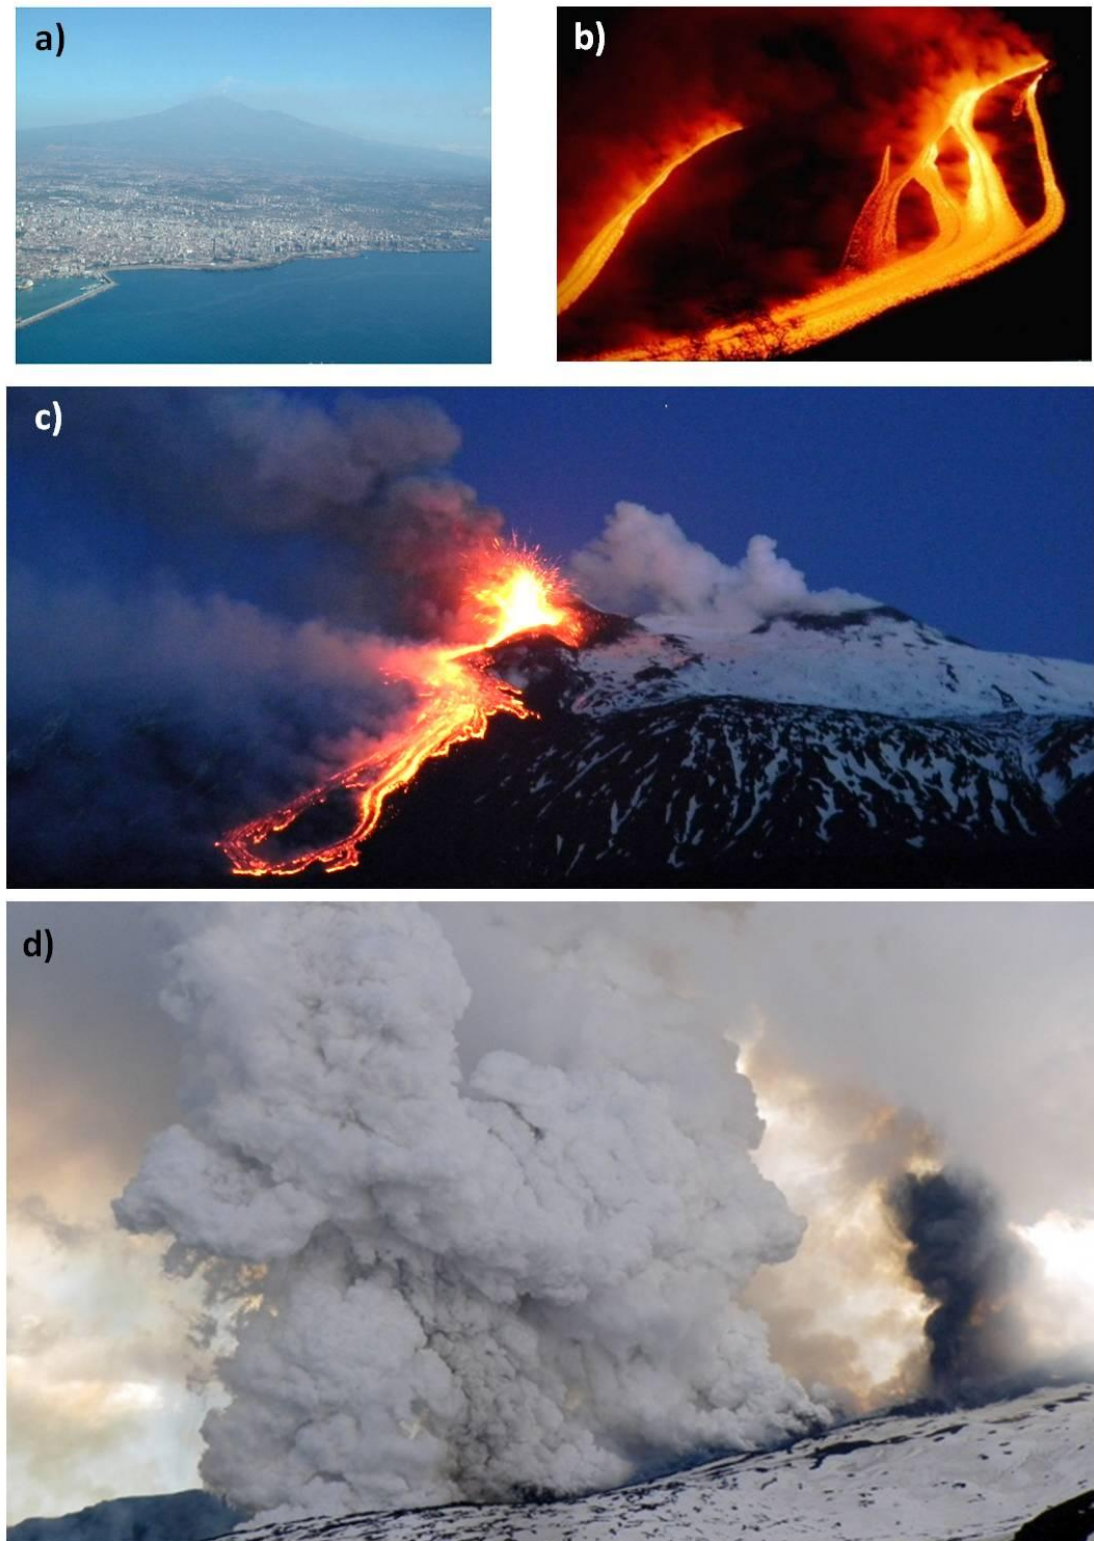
a) plume emission investing the city of Catania and other urban settlements; b) eruption and fluid lava emission (1971,by Giuseppe Scarpinati); c) final stage of emission of 12th May 2011 from Monte Fontane, East flank (by Boris Behncke); d) lava flow on the snow and strong explosions and pyroclastic flows (10th April 2011, by Francesco Ciancitto, INGV-CT)
